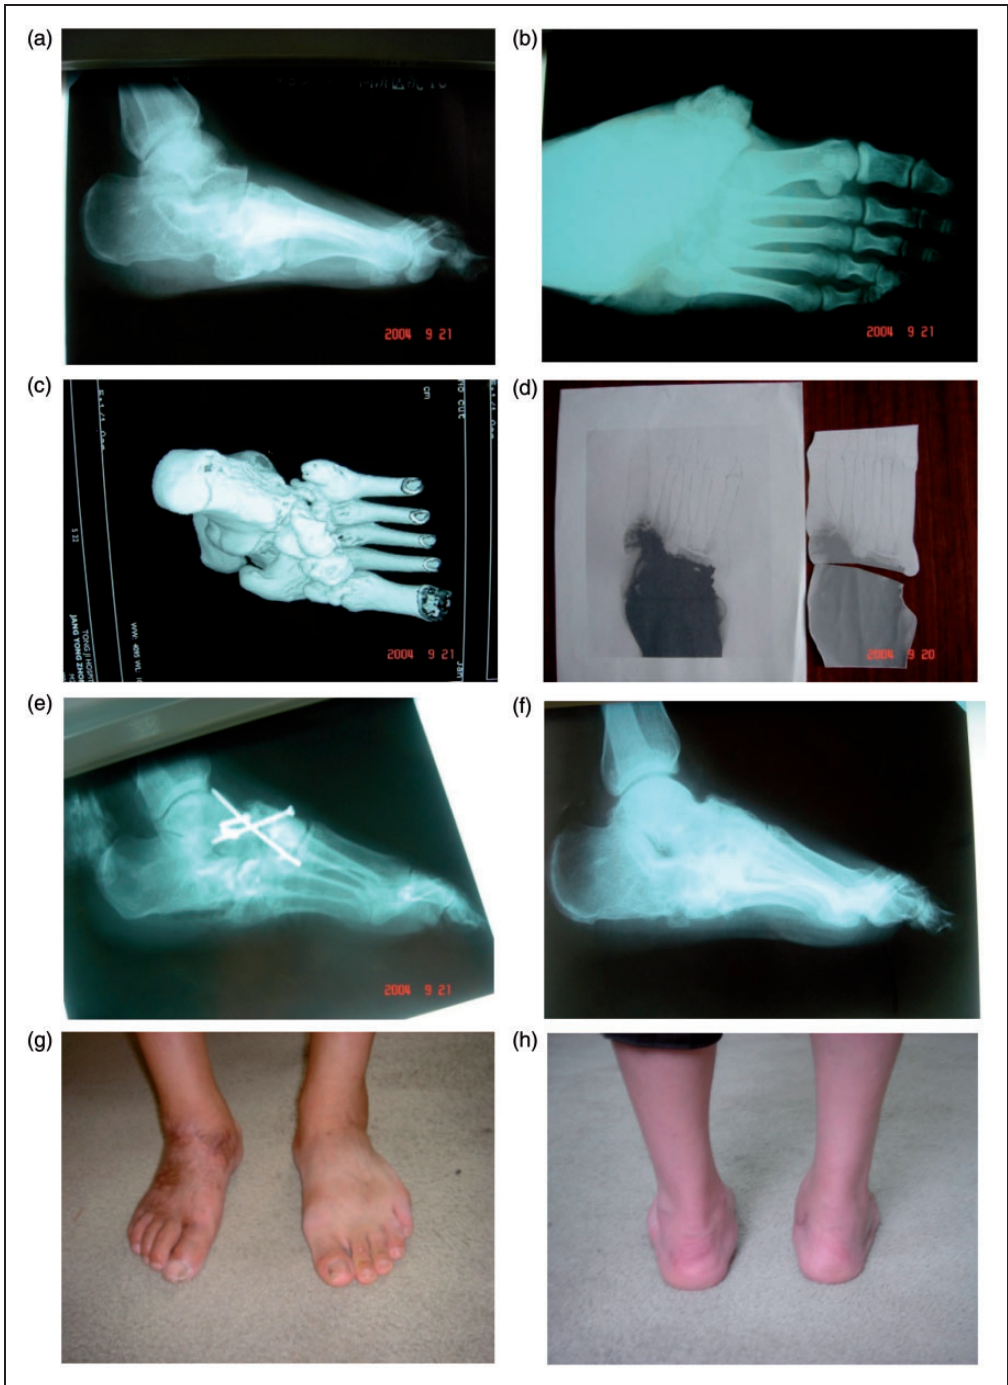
Case study: a 25-year-old man admitted to our hospital after 25 months following a foot injury. Images showing the flatfoot deformity (a–c); the preoperative design in order to decide the osteotomy width; the paper copy shows a 1:1 proportion foot X-ray print (d); X-ray following surgery to correct the collapsed arch (e); the clinical results at 12-months postoperation after removing internal fixation and arch restoration (f–h).
